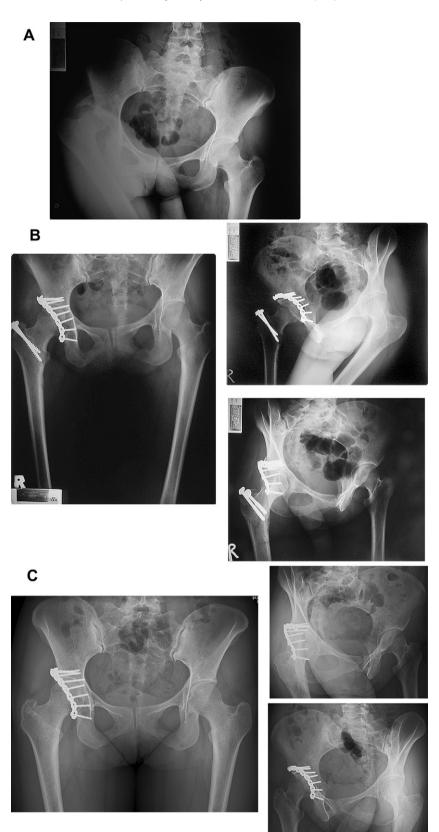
(A) Radiographs of a 25-year-old woman who had posterior wall fracture-dislocation of the right acetabulum after she was involved in a motor-vehicle accident. (B) Postoperative anteroposterior and 45° oblique radiographs. One attempt at closed reduction of the hip dislocation with the patient under general anesthesia was made. Instability of the hip joint was verified prior to ORIF. ORIF was performed with the Kocher–Langenbeck approach with transtrochanteric osteotomy. This approach was chosen because of a broader exposure necessary for the fracture site to reduce and precisely fix the fracture. (C) Anteroposterior and 45° oblique radiographs taken 4.5 years after injury. Screws for the fixation of the osteotomy were removed about 6 months after surgery because of screw impingement on the right hip when lying in the right decubitus position. The result was excellent both clinically and radiographically at final follow-up. ORIF = open reduction and internal fixation.
